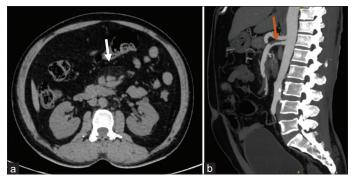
(a) Axial plain computed tomography abdomen at the level of a superior mesenteric artery (SMA) level shows subtle mesenteric fat stranding around SMA; (b) Sagittal reformatted images show linear filling defect approximately 5 mm distal to its origin, causing 50–60% luminal occlusion and extending distally
